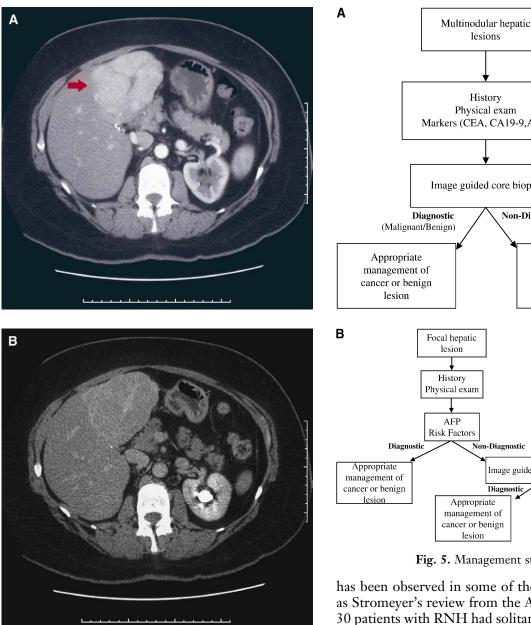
This CT scan reveals a large solitary RNH nodule in the left lobe of the liver that is hypervascular during hepatic arterial phase (A) with central scar (red arrow). This lesion is isodense during the delayed phase (B).
